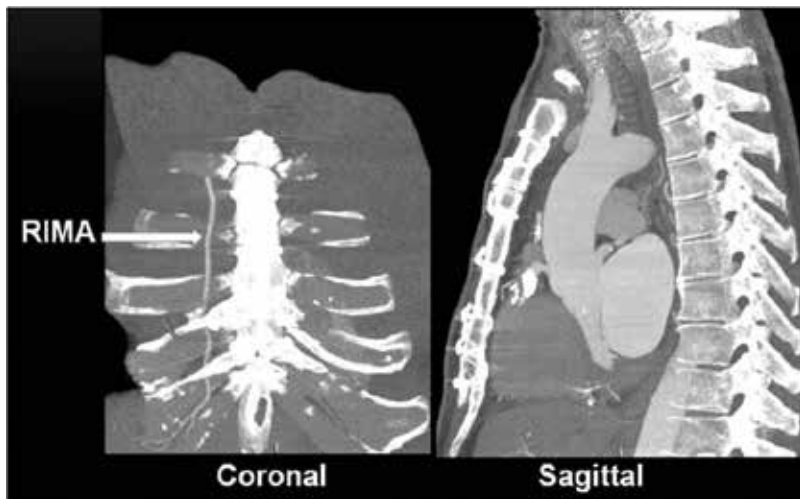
Coronal and sagittal reconstructed images of CTA of post-CABG surgery showing the status of the chest wall. The images show good healed sternum with intact wires. The left internal mammmary artery (LIMA) is not in its normal position (repositioned for arterial graft), while the right internal mammmary artery (RIMA) is present in its place.
